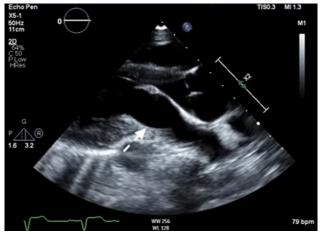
Parasternal long-axis 2D view from TTE showing mitral valve diastolic phase. The *arrow* points to the posterior mitral annulus with no visible posterior mitral leaflet.
